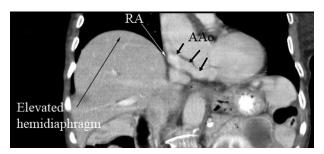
Computed tomography of the chest demonstrated elevated right hemidiaphragm (single long black arrow), horizontally positioned dilated aortic root (thick black arrows), and a small compressed and geometrically distorted RA (white arrow).
